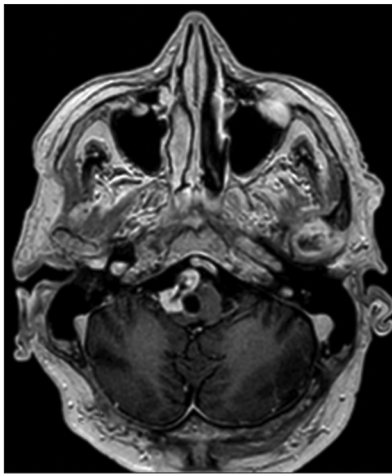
Thirteen-month follow-up axial T1-weighted contrast-enhanced MRI showing regrowth of the tumor.
